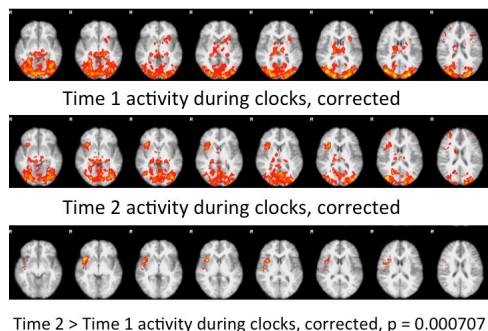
Functional MRI data during clock task at time points 1 and 2. The unique network is shown in the lowest panel.
